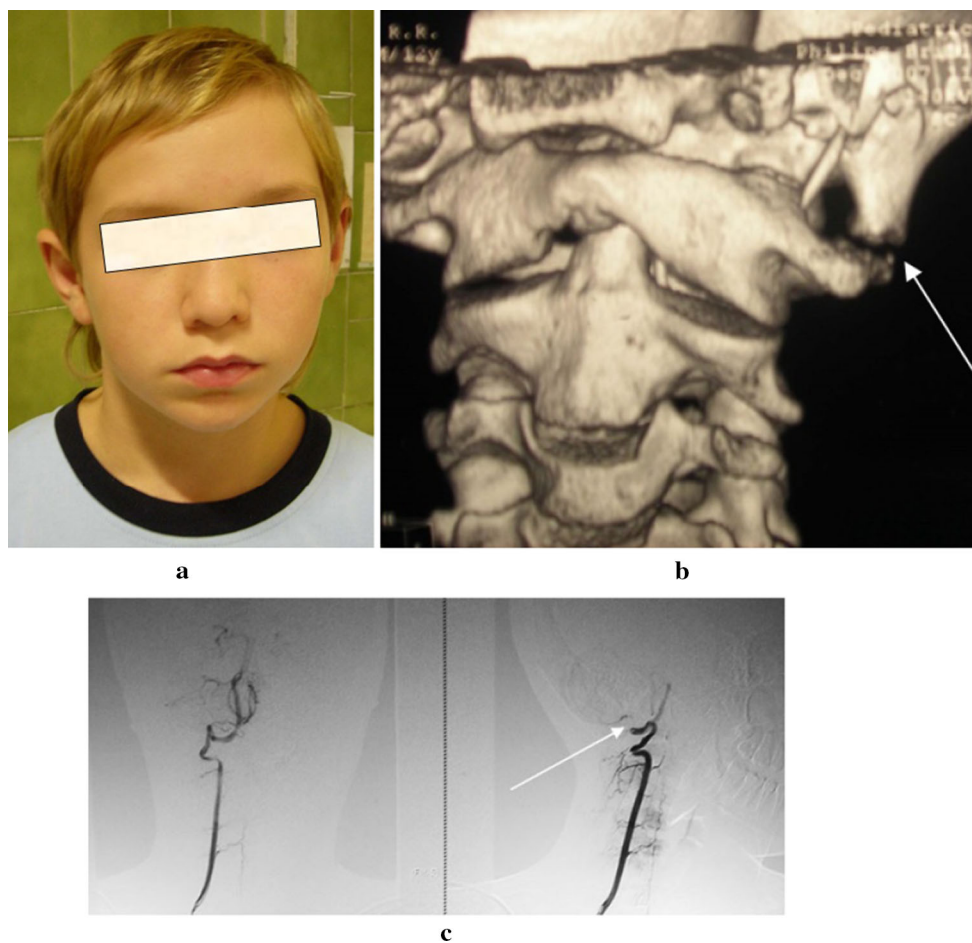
The clinical photograph (a), CT scan (b), and angiogram (c) of the 11-year-old boy (case no. 1). a Facial asymmetry and torticollis; CT scan with an atlanto-occipital outgrowth (arrow); c X-ray angiogram showing compressed vertebral artery
